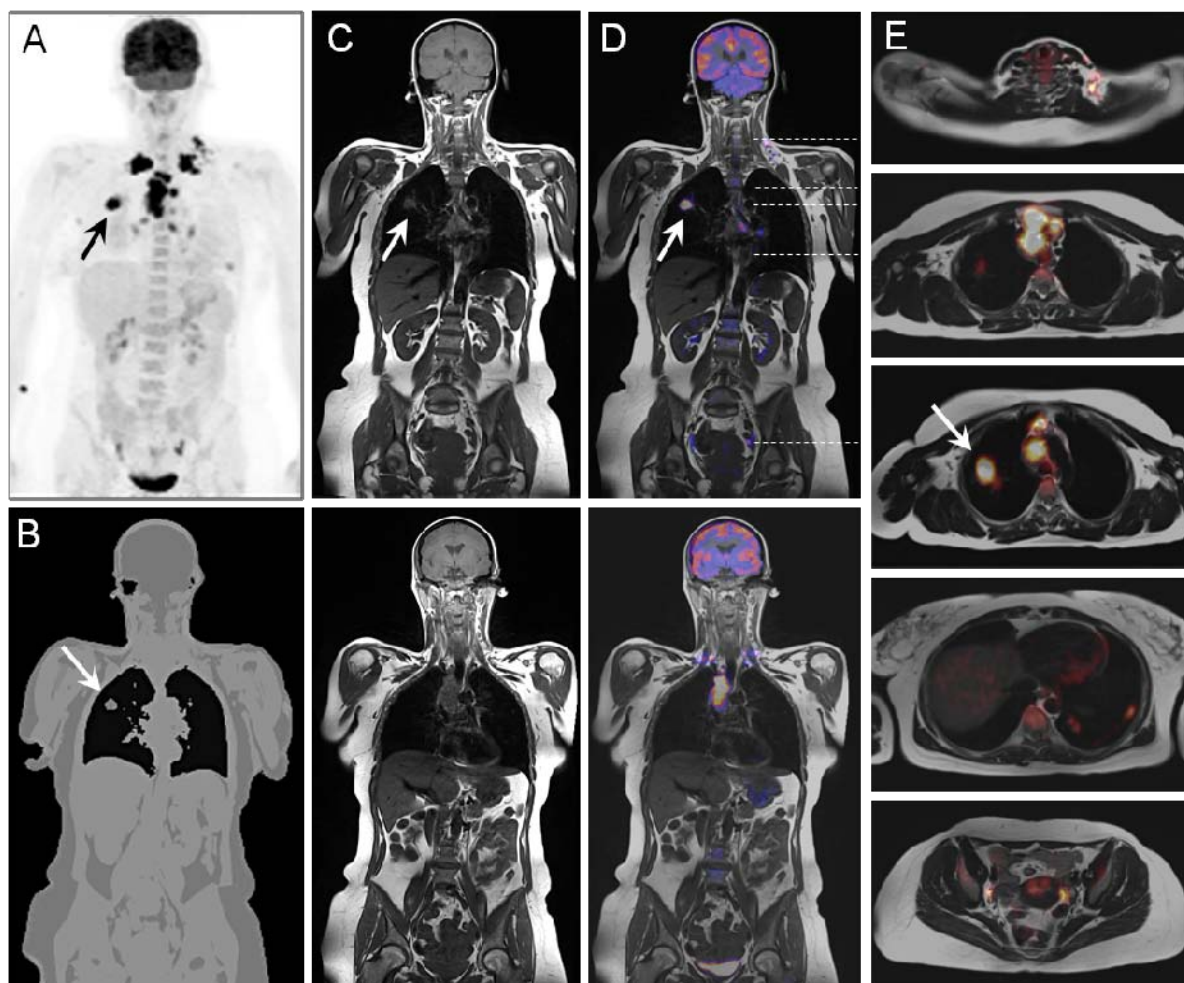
44 year old female with bronchial carcinoma (NSCLC, stage IV). (A) PET data (236 MBq F18 FDG), (B) MR-based attenuation map for AC (3D Dixon-VIBE) of human soft-tissue. (C) T1-weighted coronal views of two planes. (D) PET/MR data fusion of the two planes shown in (C). (E) Axial PET/MR views at different body levels show FDG-positive lesions in the left supraclavicular groove, ipsi- and contralateral mediastinum, and contralateral lung. There are additional FDG-positive lymph nodes in bilateral iliac lymph nodes. Arrows point to an identical lesion in different views.
